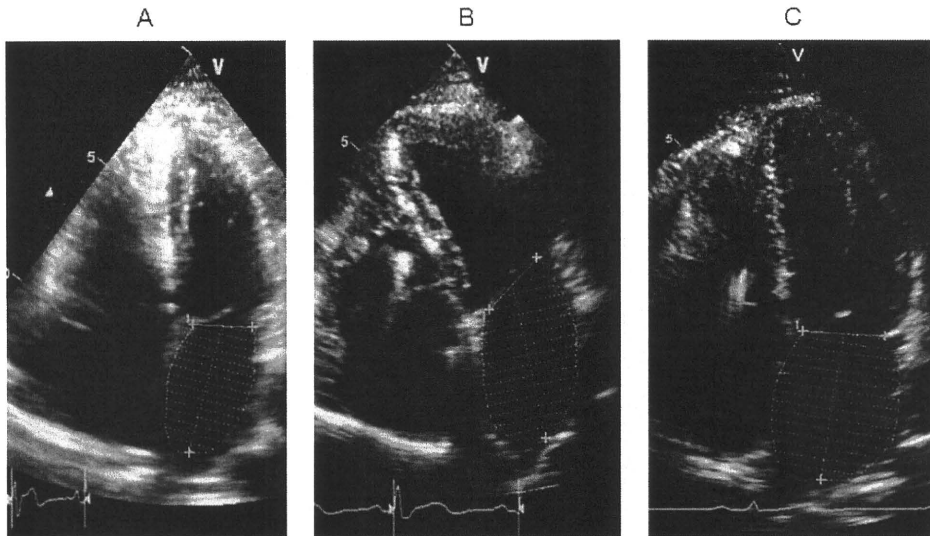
Echocardiographic measurements of left atrial volume in patients with Brugada syndrome. A: A patient without VF and AF. LAVI was 20 ml/m². B: A patient with VF and without AF. LAVI was 29 ml/m². C: A patient with VF and AF. LAVI was 33 ml/m². These were recorded from the same patients as those for which results are shown in Figure 1. LAVI = left atrial volume index; other abbreviations as in Figure 1.
